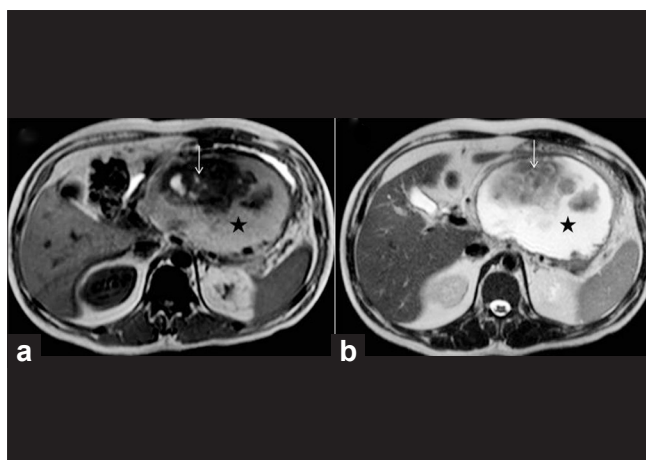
Pancreatic pseudocyst in a 50-year-old male who presented after an episode of pancreatitis. Axial T1W (a) and T2W (b) MR images of abdomen show a large, walled-off cystic lesion localized to lesser sac (asterisk). The lesion shows internal debris along with hemorrhage (arrow). Presence of internal debris is a highly specific MR finding for diagnosing pseudopancreatic cyst
